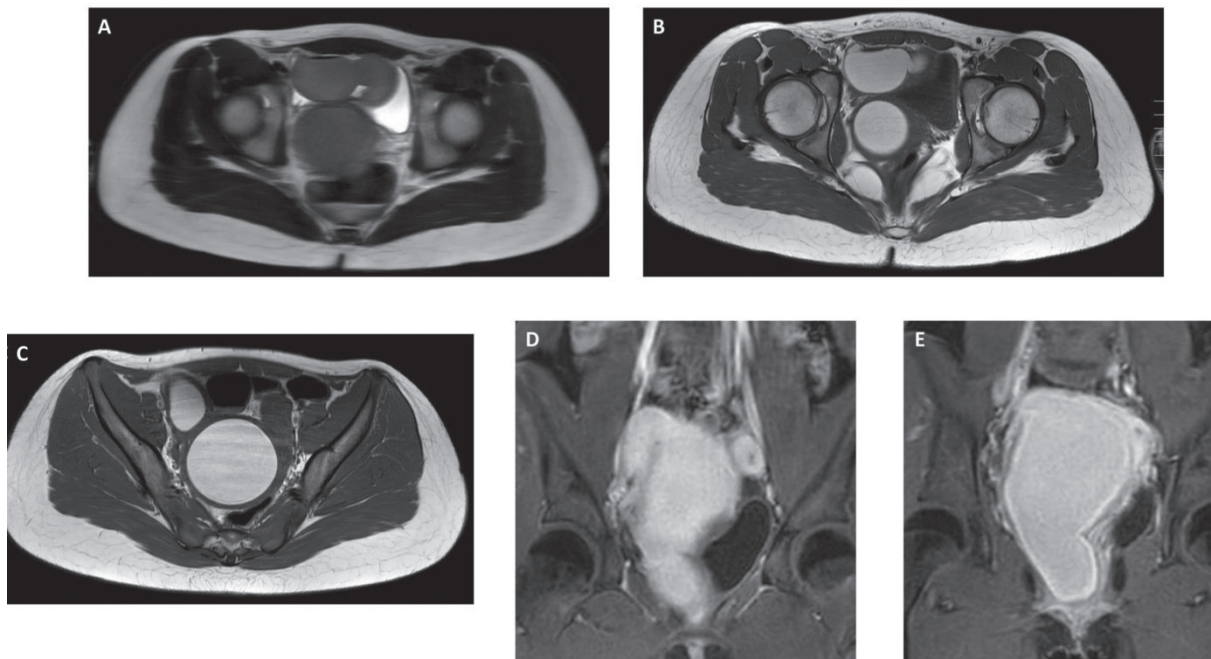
Magnetic Resonance Images. (A) Axial T2W images; (B), (C) Axial T1W images; (D), (E) Coronal T1W contrast-enhanced images.
